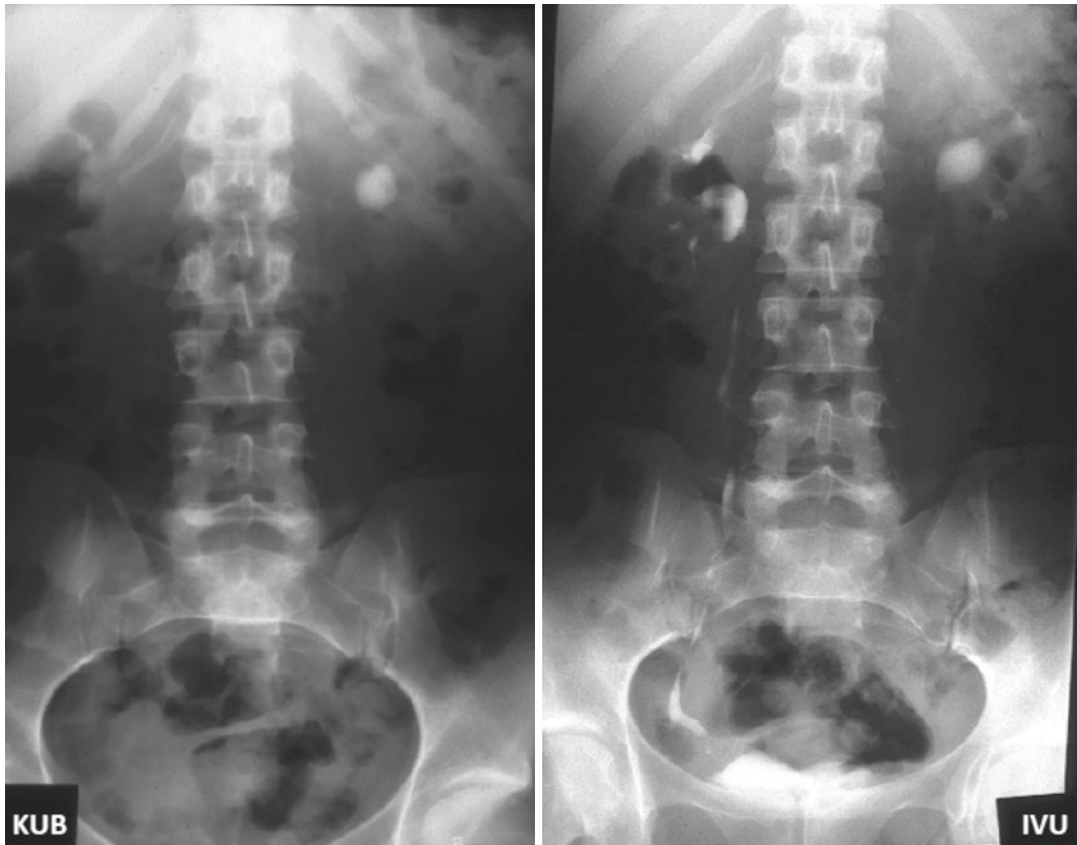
Plain abdominal radiography [KUB] and intravenous urography [IVU]. (KUB [left] showing large radiopaque stone in the left kidney. IVU [right] demonstrating
